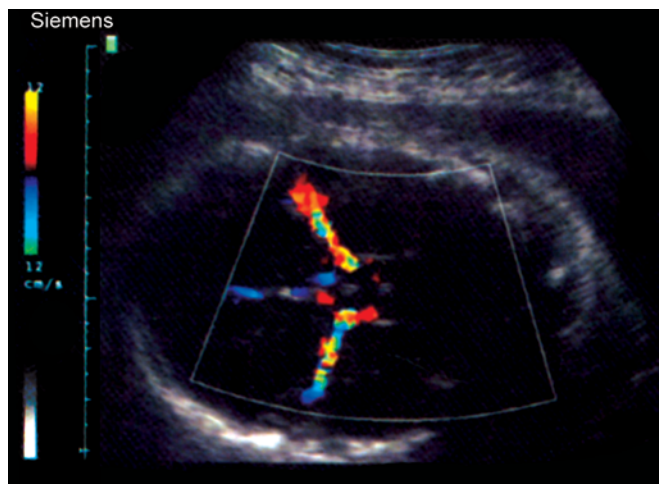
Circle of Willis and middle cerebral artery visualized with color Doppler
